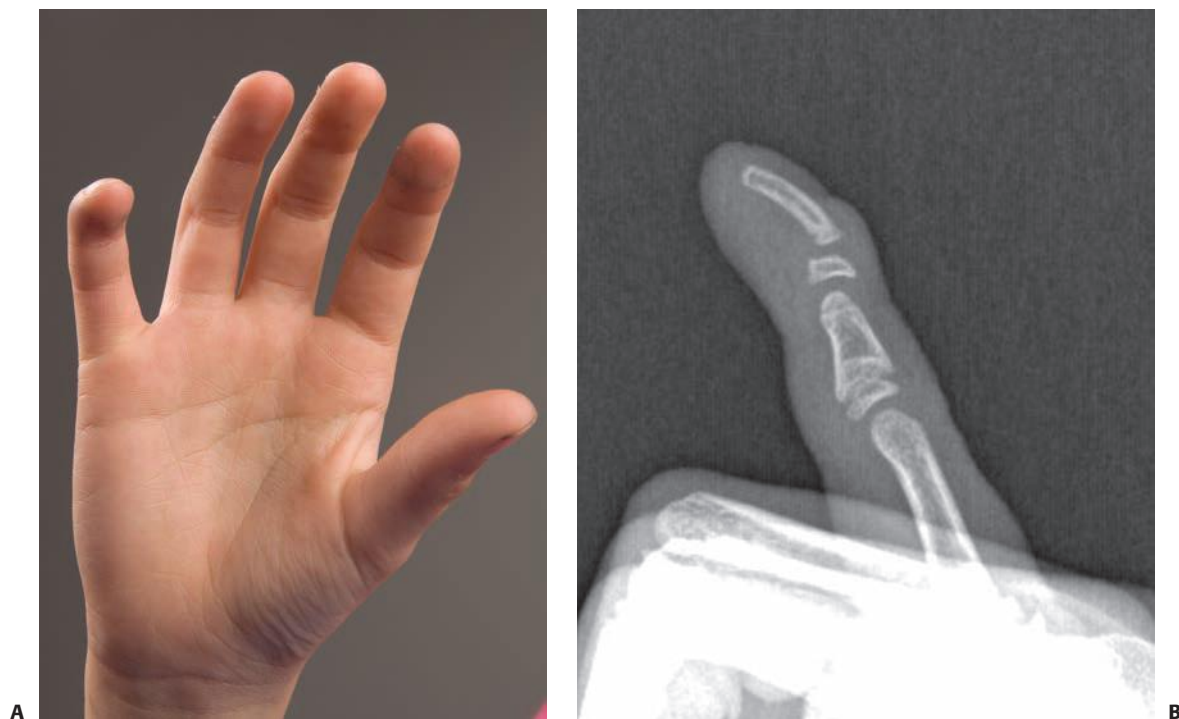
A–B: A 9-year-old girl with incurving of the tip of the right small finger. Similar findings are noted in family members. The AP and lateral radiographs show radial and palmar incurving of the distal phalanx characteristic of Kirner deformity.
